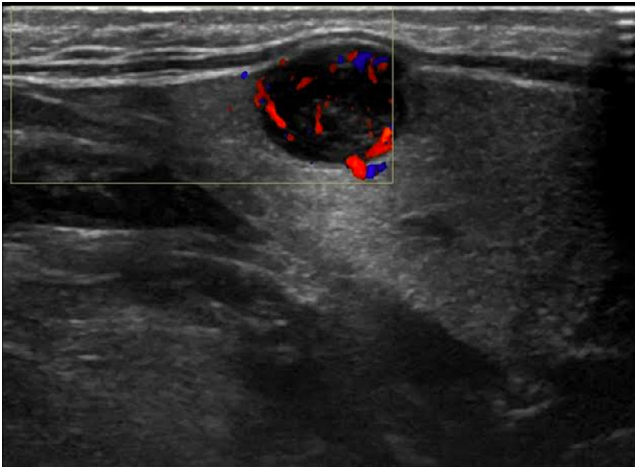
Ultrasound scan showing heterogeneous echogenicities in left submandibular gland lesion and increased Doppler signal within lesion
